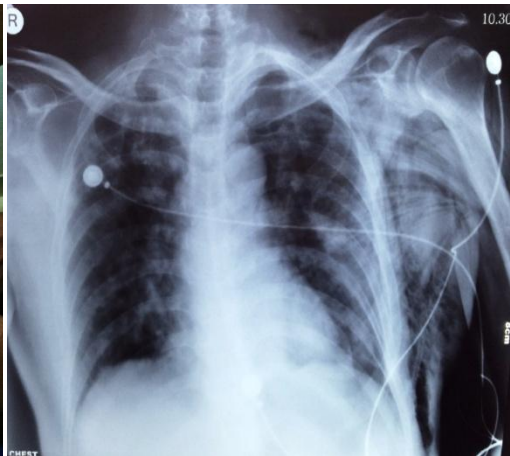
chest X-ray AP sitting (in ICU)
